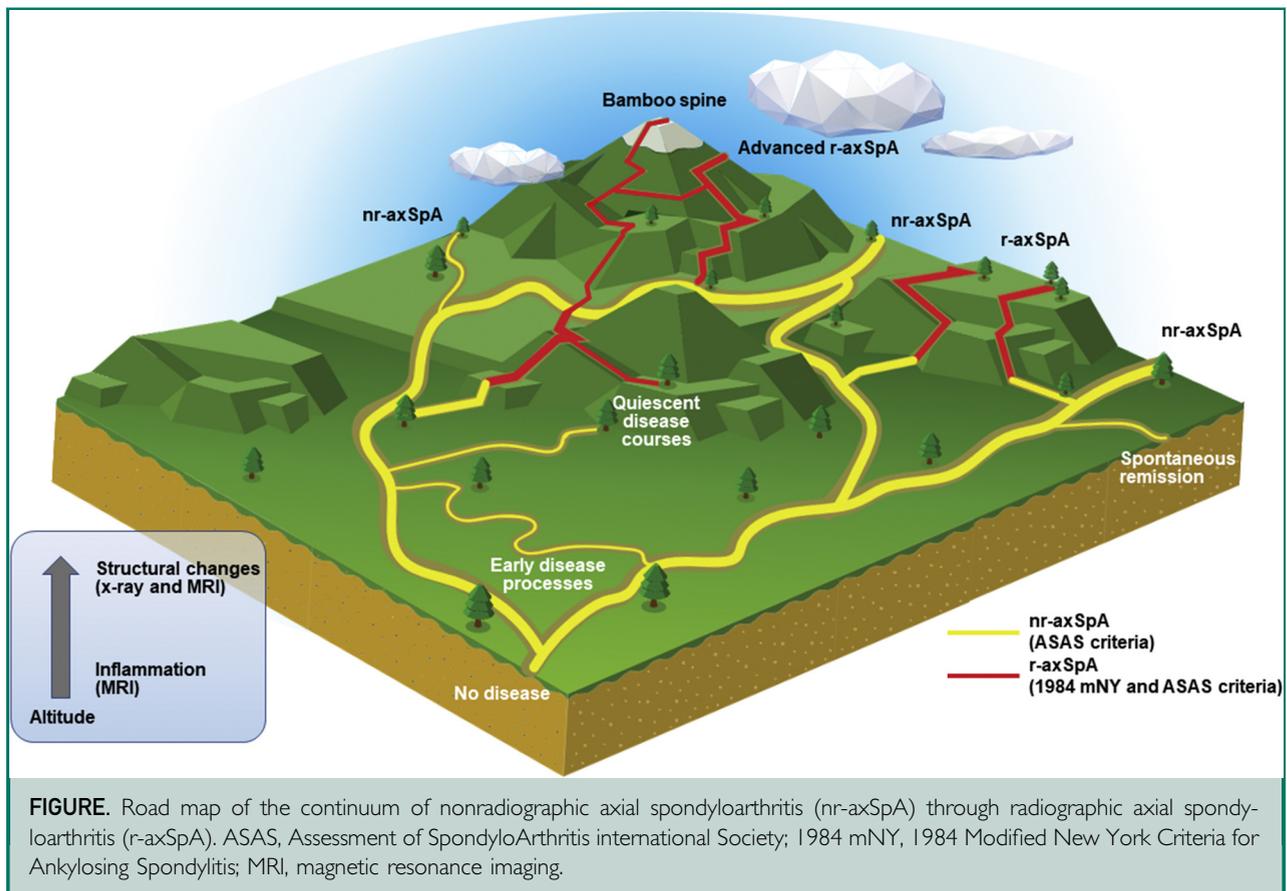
Road map of the continuum of nonradiographic axial spondyloarthritis (nr-axSpA) through radiographic axial spondyloarthritis (r-axSpA). ASAS, Assessment of SpondyloArthritis international Society; 1984 mNY, 1984 Modified New York Criteria for Ankylosing Spondylitis; MRI, magnetic resonance imaging.
